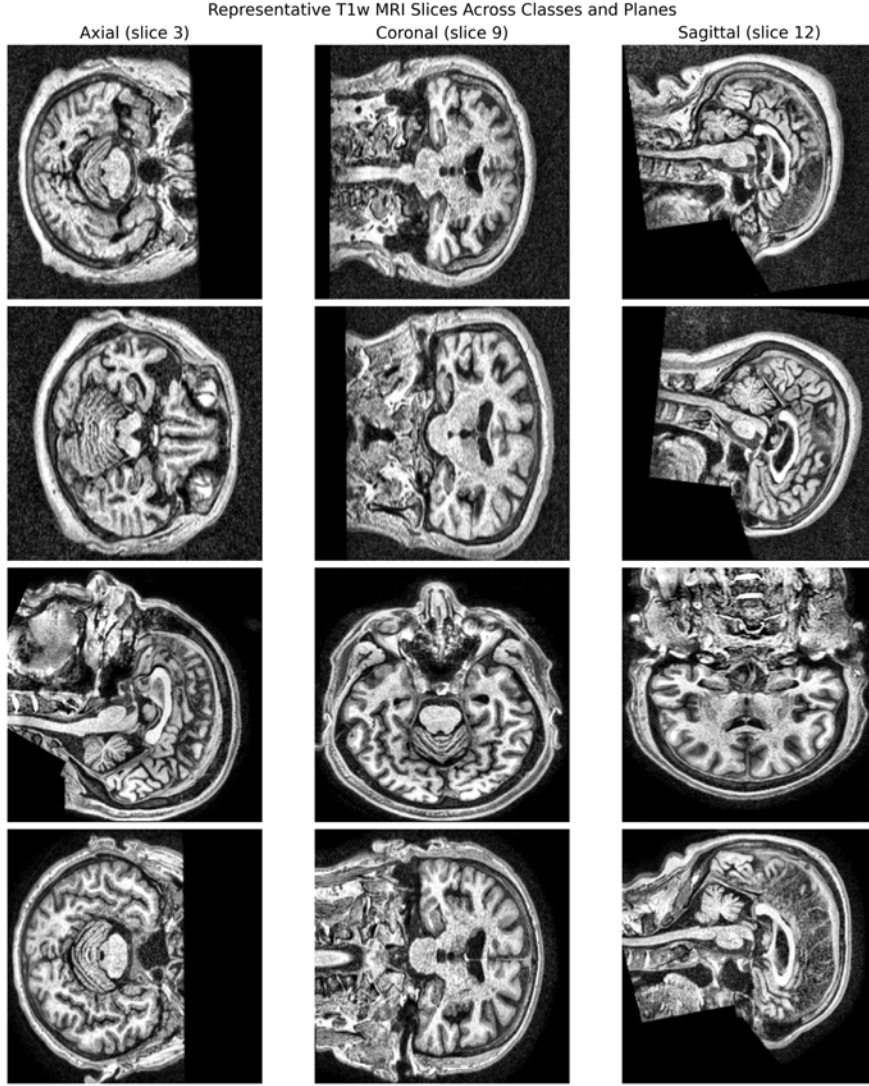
Representative T1w MRI slices across four classes and three anatomical planes.
